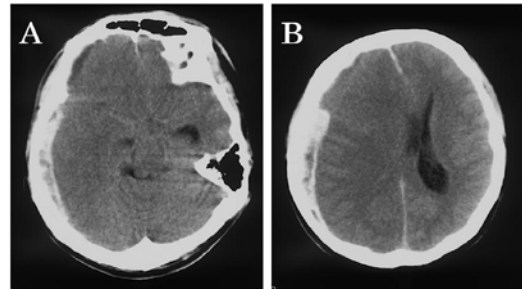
Case 2, a 35-year-old man injured in a soccer match. Head CT (axial image). CT shows a right ASDH and mid-line shift.
